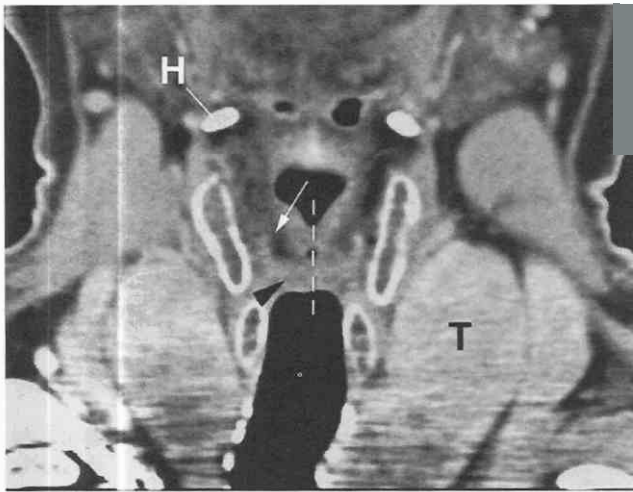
Reformatted coronal image through the larynx (multidetector CT). The patient is holding his breath. The position of the closed airway is represented by the *dashed line*. Note the density of fat in the paraglottic space at the supraglottic level (*arrow*). The thyroarytenoid muscle (*arrowhead*) forms the bulk of the true cord (glottic level). The thyroid cartilage and cricoid cartilage are also visible. H, hyoid bone; T, thyroid gland.
